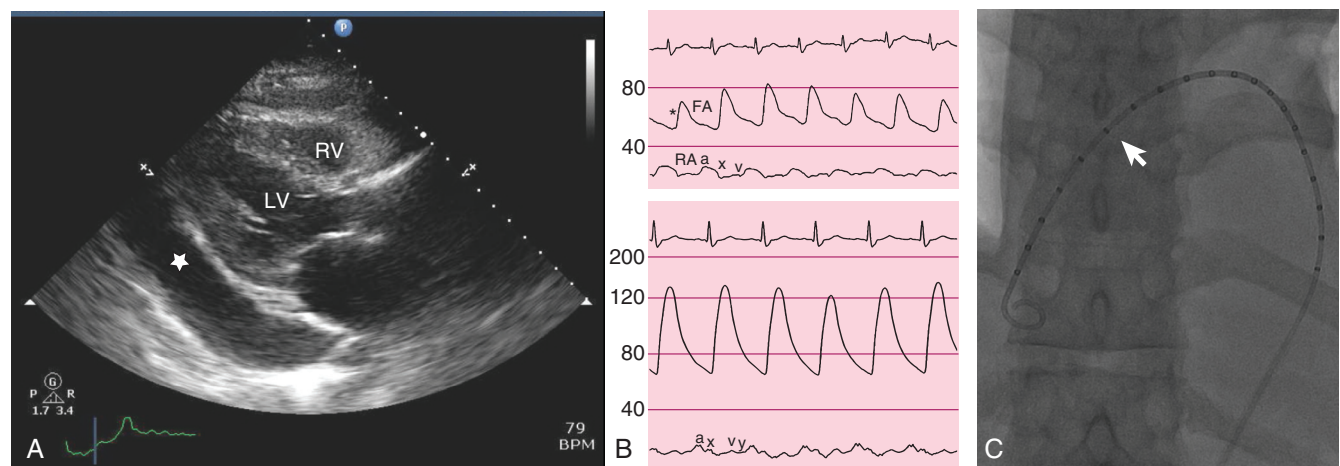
■ A, Echocardiogram in the parasternal long axis view demonstrating a large circumferential pericardial effusion (*star*). B, Hemodynamic tracings demonstrate hypotension and pulsus paradoxus (asterisk) in the femoral artery (FA) pressure tracing and loss of the y descent in the right atrial (RA) pressure tracing (*top*). After pericardiocentesis, there is an increase in arterial pressure and return of the y descent in the RA pressure tracing (*bottom*). C, Pericardial drain (*arrow*) in the pericardial space. LV, Left ventricle; RV, right ventricle. (B, From Sorajja P: Invasive hemodynamics of constrictive pericarditis, restrictive cardiomyopathy, and cardiac tamponade. *Cardiol Clin* 29:191–199, 2011.)
